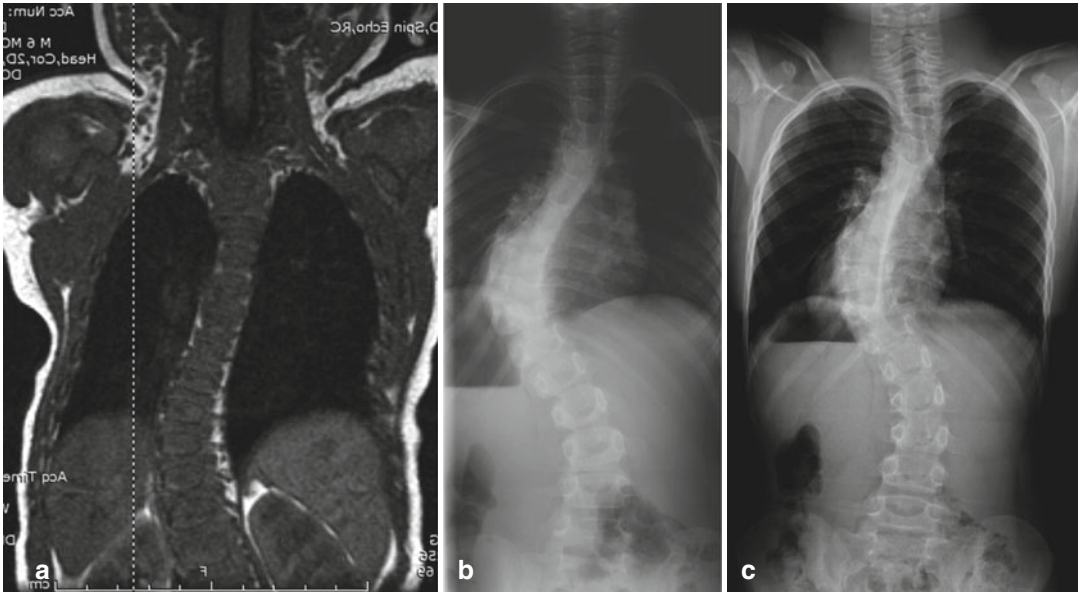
Idiopathic early onset scoliosis. Bracing was begun at age 20 months with thoracic Cobb angle of 60° (MRI at 18 months of age (a)) and has been continued full-time in a TLSO (age of 6 years seen on (b)), with an emphasis on allowing chest expansion opposite the pressure pads. By the age of 11 years, the curve has increased
